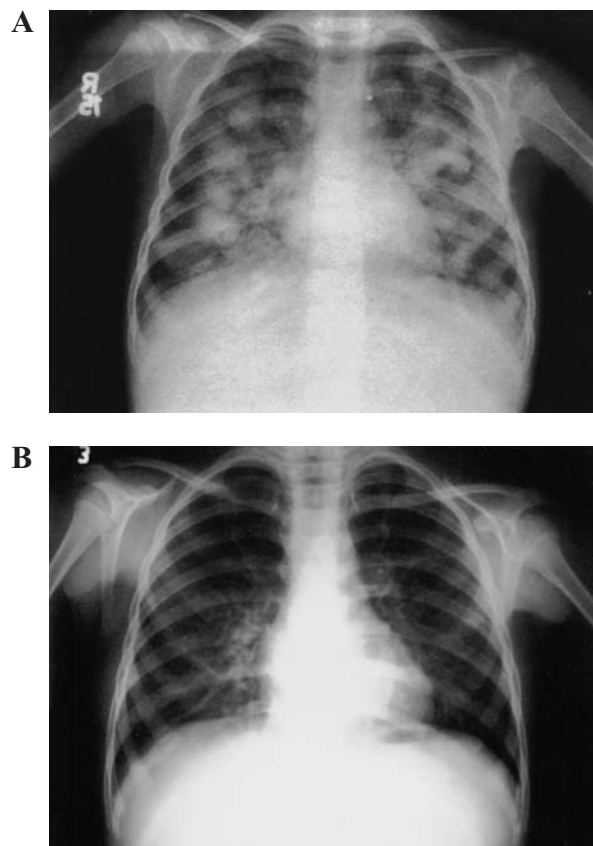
Chest x-ray. Widespread cysts before (A) and 13 months after (B) mebendazole treatment.
